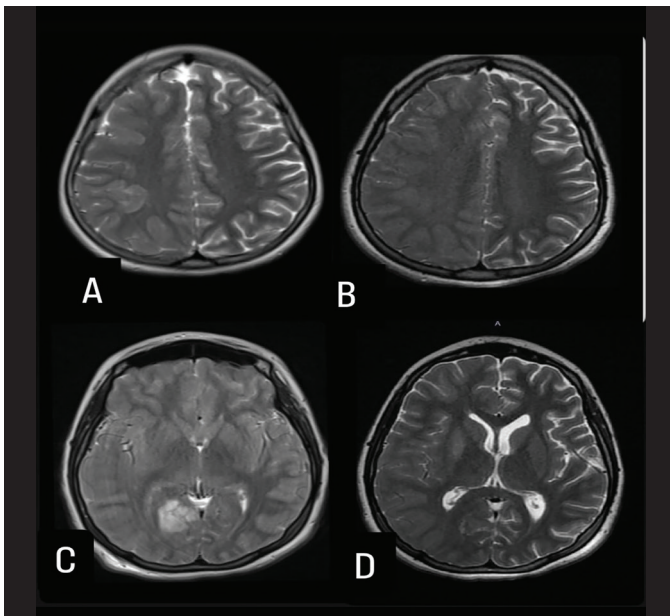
A) Cortical thickening and dysgyria are observed in the right frontoparietal area. This is considered to be focal cortical dysplasia. B, C) The right hemisphere of the brain appears edematous compared with the left hemisphere. Hyperintensity is observed in the right occipital cortex on T2A and FLAIR sequences. D) On the control MRI performed after immunotherapy, we observed that the hyperintensity on T2 and FLAIR imaging in the right occipital region disappeared
